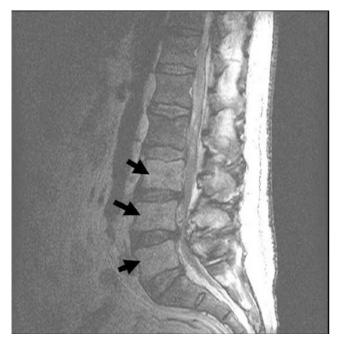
Marrow signal intensity at L3, 4, 5 levels with epidural abscess from T11 to L3 (black arrow), T2-weighted image
